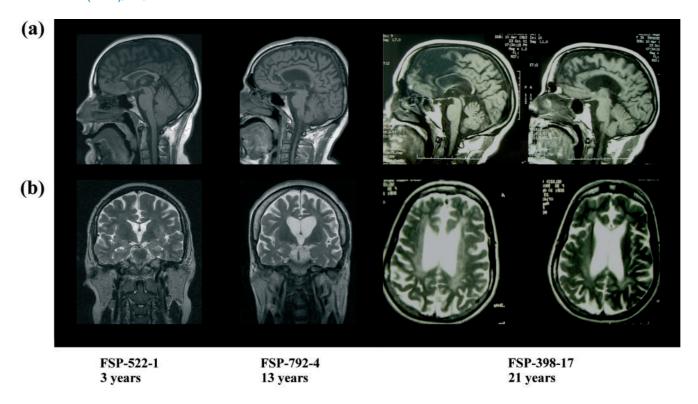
Brain MRI images of three patients with different disease durations. (A) TI-weighted sagittal image showing thin *corpus callosum* and global cortical atrophy, (B) T2–Fast Spin Echo weighted axial and coronal images showing periventricular hyperintensities of variable severity according to disease duration.
